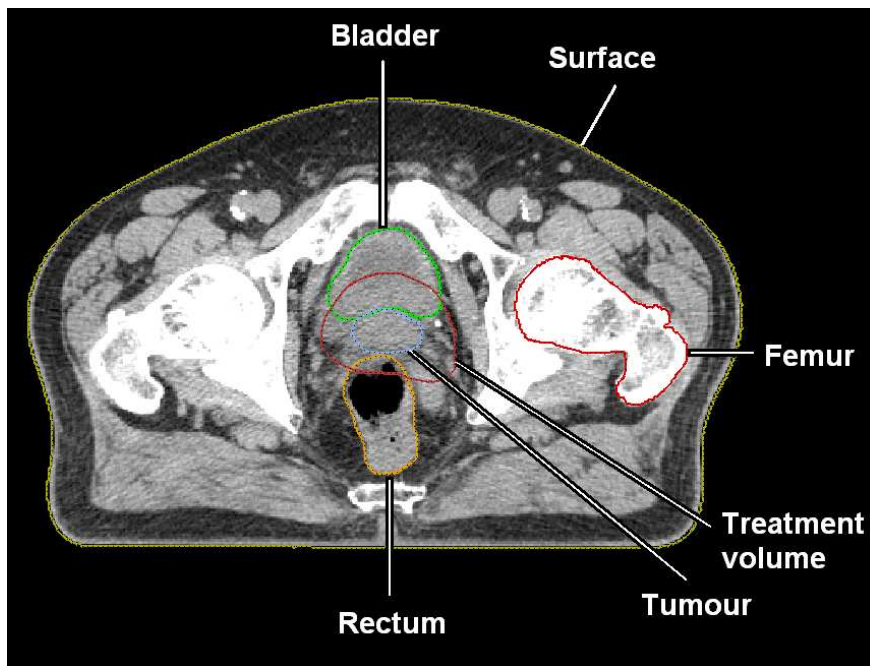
Pelvic CT scan of a patient with prostate cancer.
